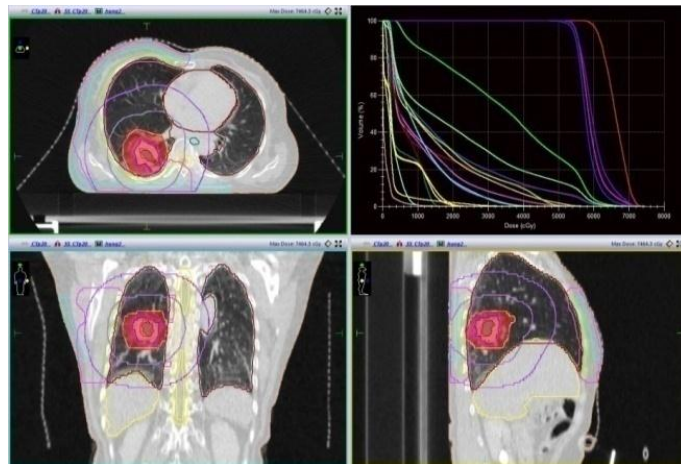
Isodose curve shown on CT images (lung).
